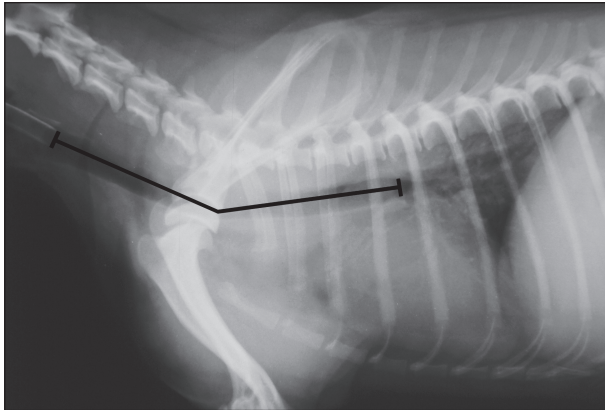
Lateral radiograph of the neck and the chest. The length of the trachea was measured to estimate length of the stent.
